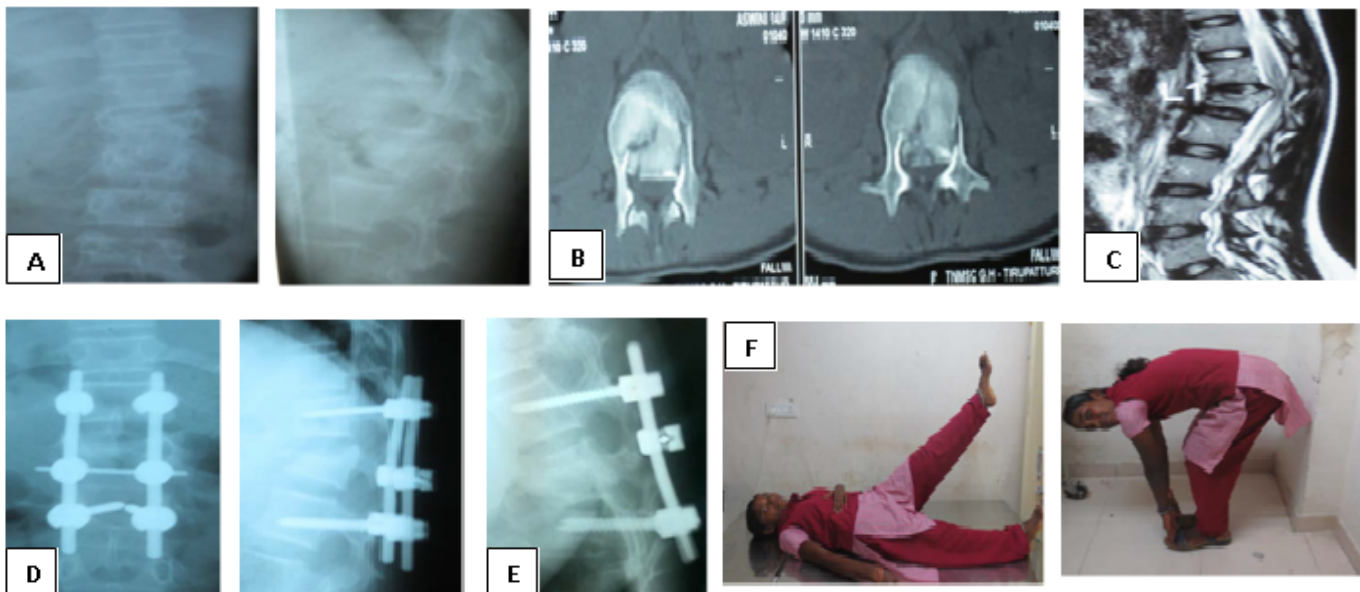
Case of 15 years old female with AO Type A Fracture L1 Vertebrae (A) Preoperative X-ray AP and Lateral views, (B) Preoperative CT Image, (C) Preoperative MRI Image, (D) Immediate Postoperative X-ray AP and Lateral views, (E) X-ray Lateral view 1 year Follow up, (F) Clinical images 1 year follow up
